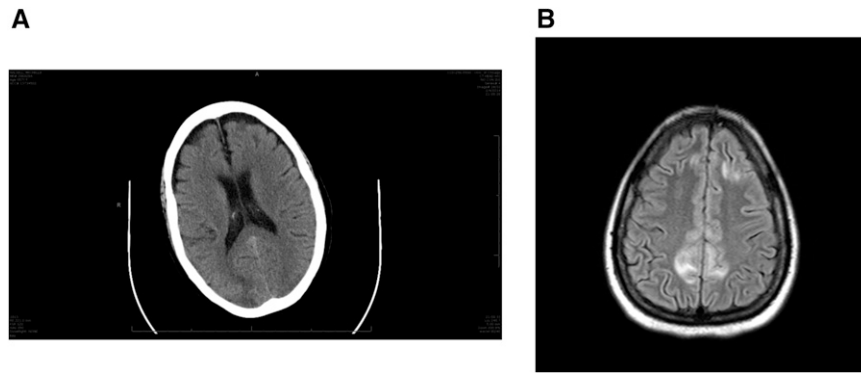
Brain imaging studies. (A) Head CT. (B) Brain MRI. CT, computed tomography; MRI, magnetic resonance imaging.
